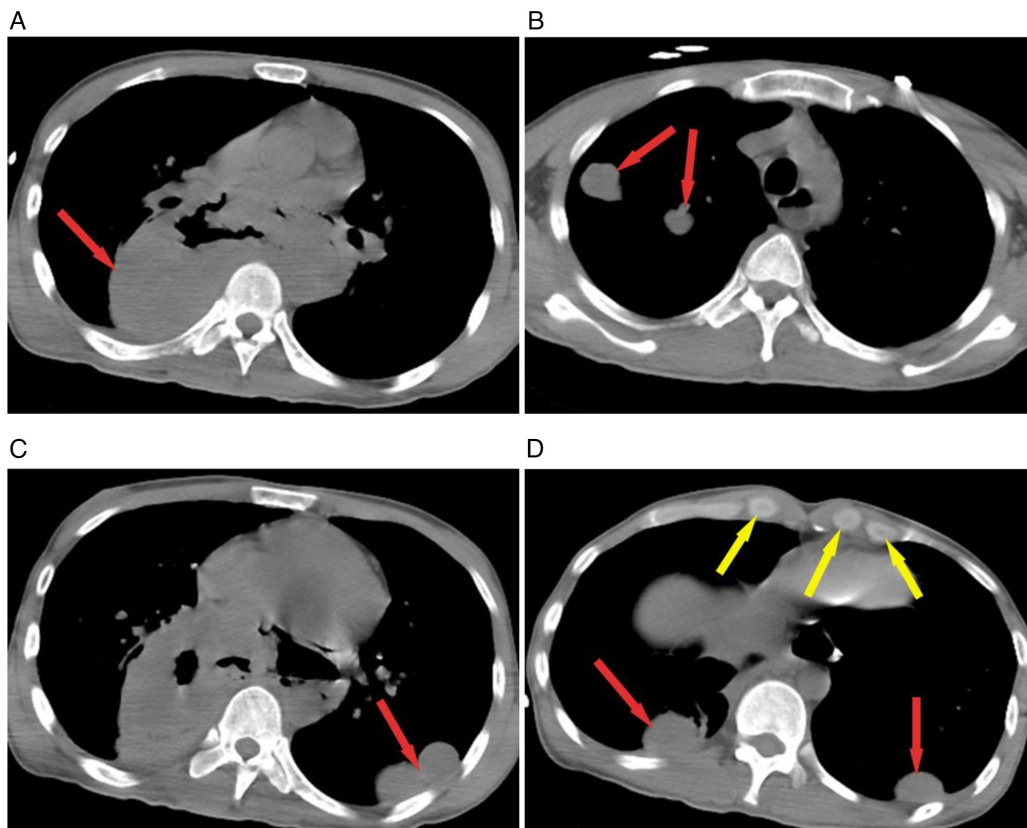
Chest CT changes in mediastinal window and lung window. (A) Chest CT scan showing a 13.6x6.6-cm huge mass with pneumatosis of the posterior mediastinal. (B and C) Multiple nodules (red arrows) of varying sizes are present in the upper and lower lobes of both lungs and the larger ones were ~3.5x2.7-cm in the lower lobe of the left lung. (D) Chest CT showing multiple nodules (yellow arrows) in both supraclavicular regions and the larger ones measuring ~1.8-cm in diameter. CT, computed tomography.
